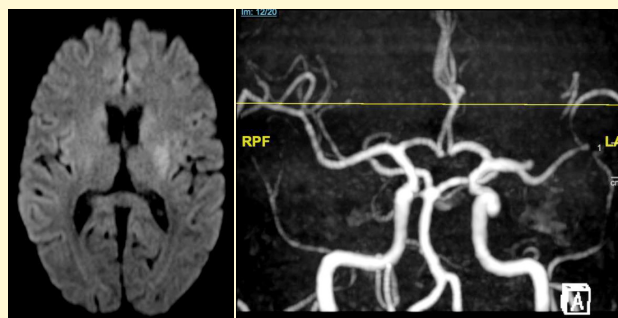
DWI image showing acute infarct in left lentiform nucleus. MRA frontal MIP projection showing cut off of superior division of left MCA.
